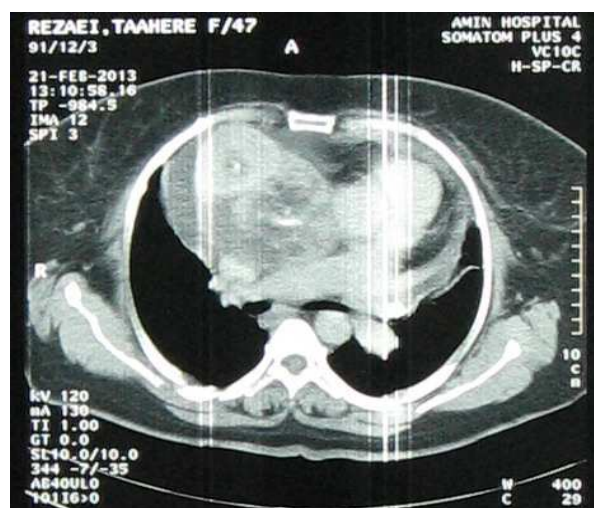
Pre-operative computed tomography showing a large (10 × 7 cm) superior mediastinal mass containing calcific density foci
